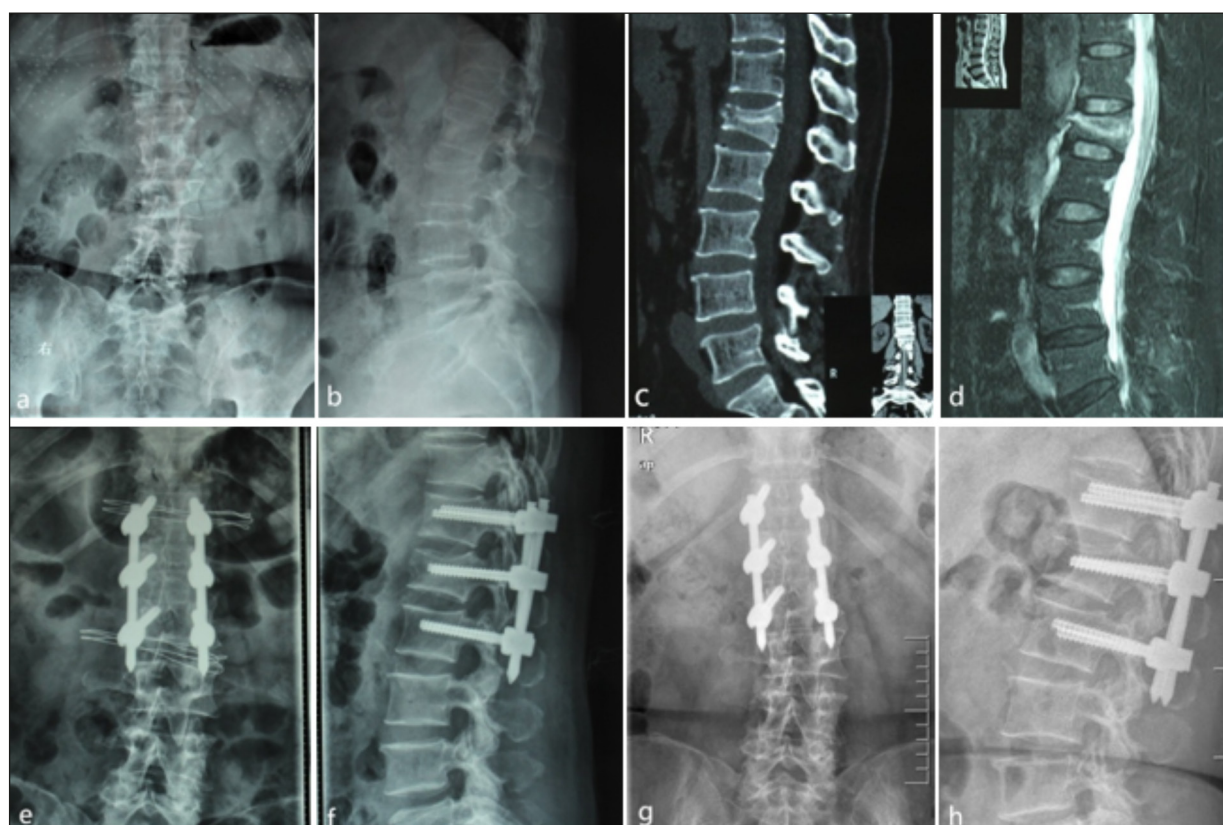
Typical case: A female patient of 55 years old was admitted to the hospital with low back pain and limited movement for 5 hours due to a car accident. The admission diagnosis was L₁ compression fracture, and percutaneous single plane screw internal fixation was performed in our hospital. a-b, Preoperative frontal and lateral X-ray films showed L₁ compression fracture and thoracolumbar kyphosis. c-d, Preoperative CT and MRI showed that there was no spinal canal bone space occupying and no spinal cord injury. e-f, Frontal and lateral X-ray films immediately after surgery show deformity correction and restoration of L₁ vertebral body height. g-h, Anterior and lateral X-ray films at the last follow-up showed no remarkable height loss of the injured vertebra.
